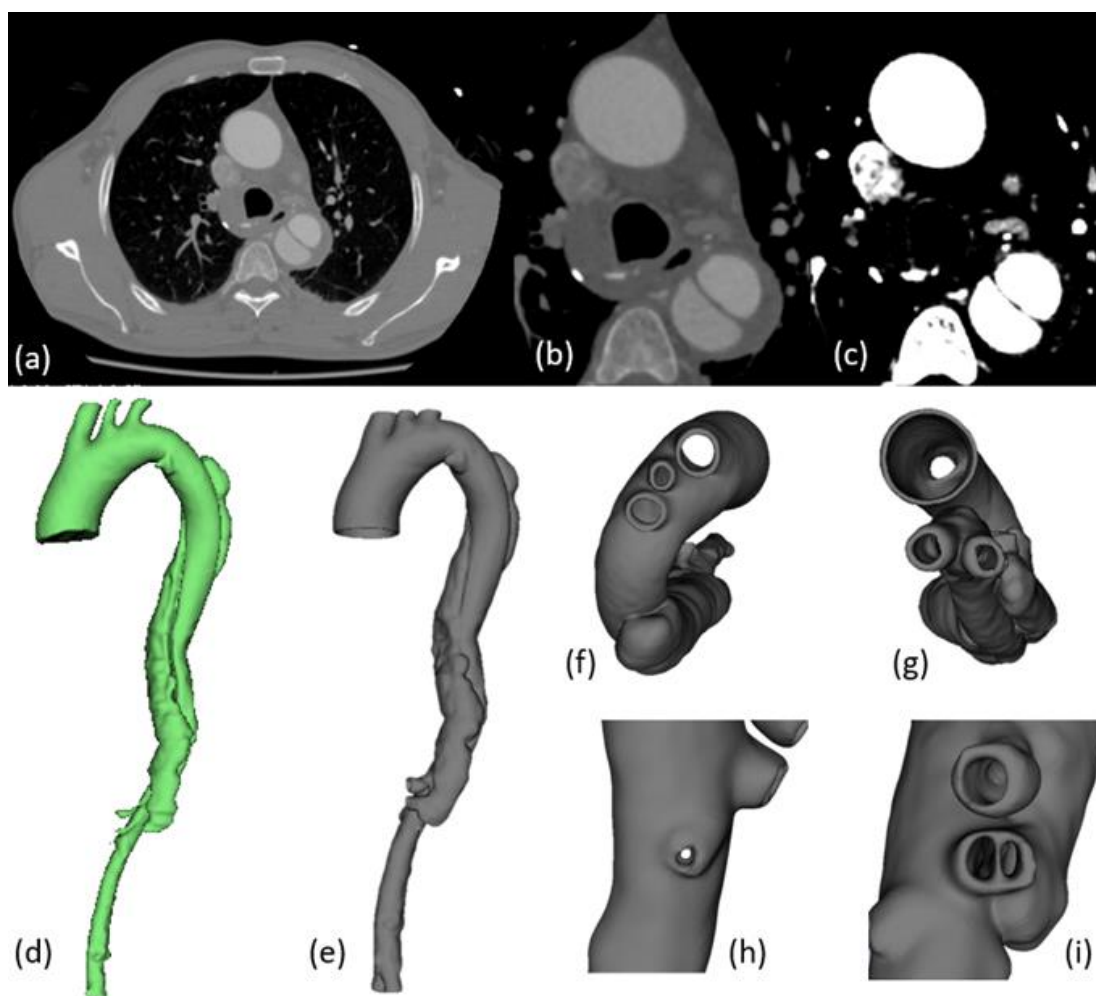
Developed protocol for image processing and segmentation of type B aortic dissection. (A) Original computed tomography image. (B) Image cropping. (C) Image after applied de-noising and contrast enhancement filters. (D) Reconstruction and extraction of the lumen. (E) Final outcome of the Standard Tessellation Language (STL) model. (F) STL model top view. (G) STL model bottom view. (H) Renal artery on the STL model. (I) Celiac trunk and superior mesenteric artery on the STL model.
